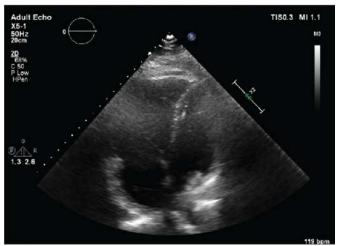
Transthoracic echocardiogram demonstrating RV dilation
